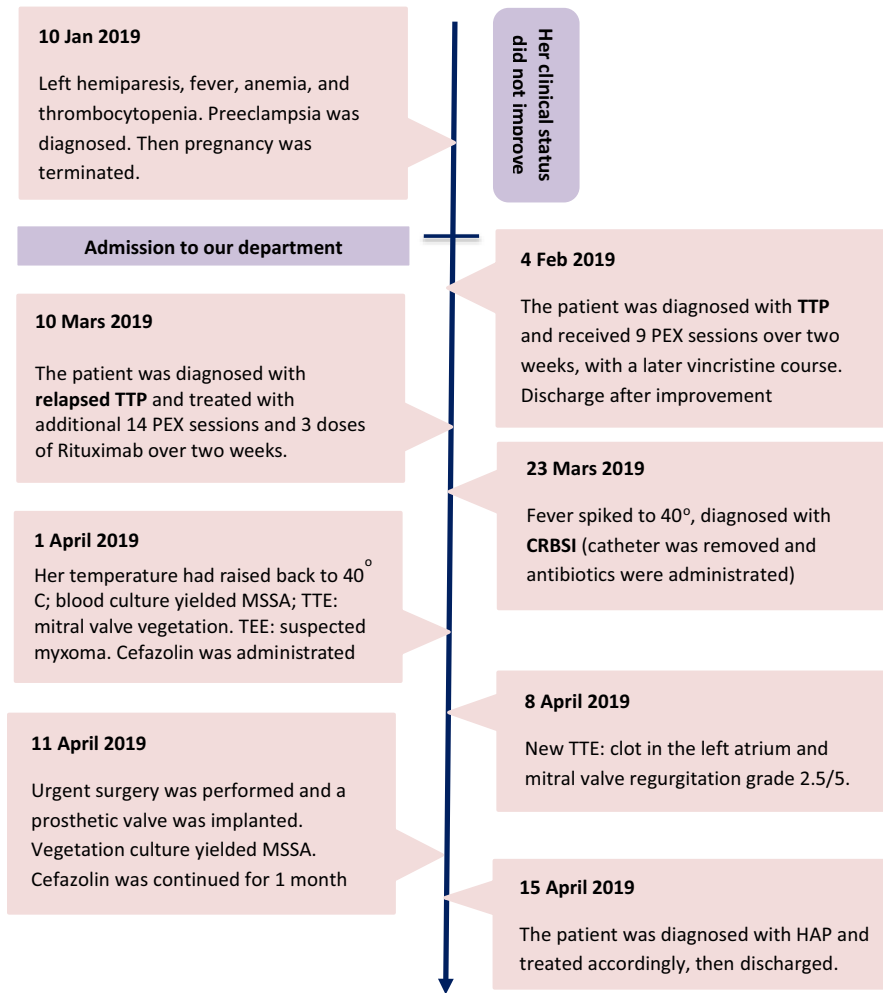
Timeline of the patient's case, diagnostic process, intervention, and outcome. TTP: Thrombotic thrombocytopenic purpura, PEX: Plasma exchange, CRBSI: Catheter-related bloodstream infection, MSSA: Methicillin-sensitive *Staphylococcus. Aureus*, TTE: Transthoracic echocardiography, TEE: Transesophageal echocardiography, HAP: Hospital-acquired pneumonia
